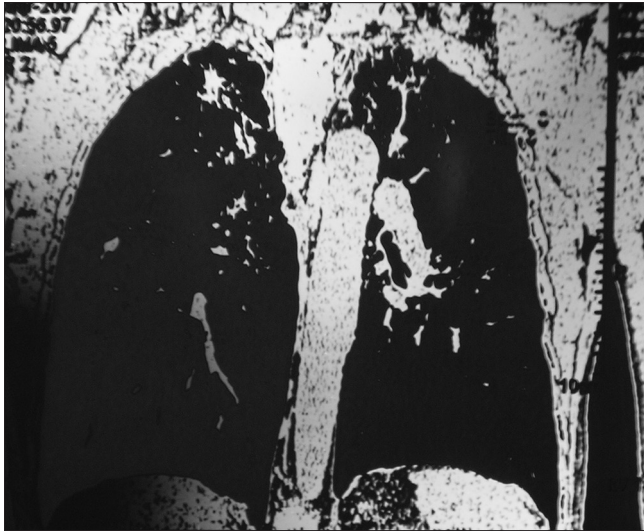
Contrast enhanced computed tomography chest showing miliary nodules along with subpleural involvement with interlobular peribroncho-vascular thickening and interspersed areas of consolidation
